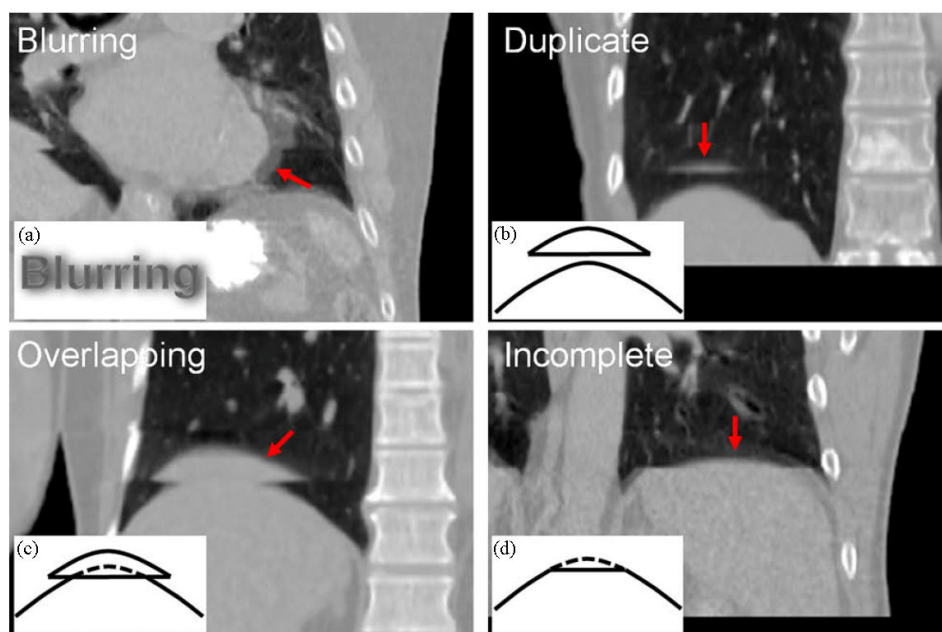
Classification of 4D-CT artifacts. (a) Intra-slice artifact. (b-d) Inter-scan artifacts. Adapted from *Yamamoto et al.*⁶⁵
